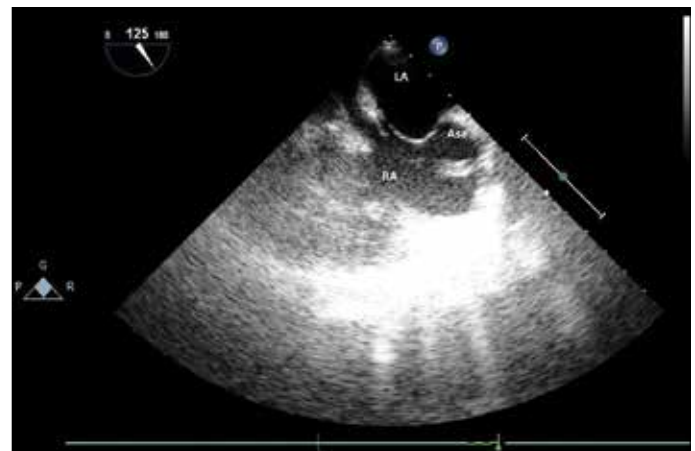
Transesophageal echocardiographic image showing an atrial septal aneurysm and cor triatriatum dexter
